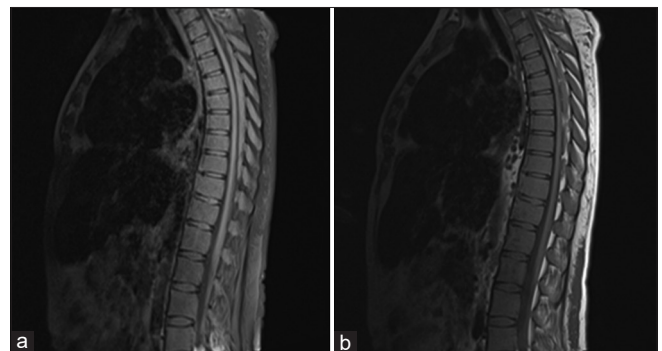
Follow-up magnetic resonance imaging after 2 years of radiation therapy (a) sagittal T1 and (b) postcontrast T1 with fat sat-weighted images showing interval regression in size of enhancing posterior epidural masses in the thoracic region with interval improvement of compression on the thoracic cord which shows subtle high T2 signal alteration
